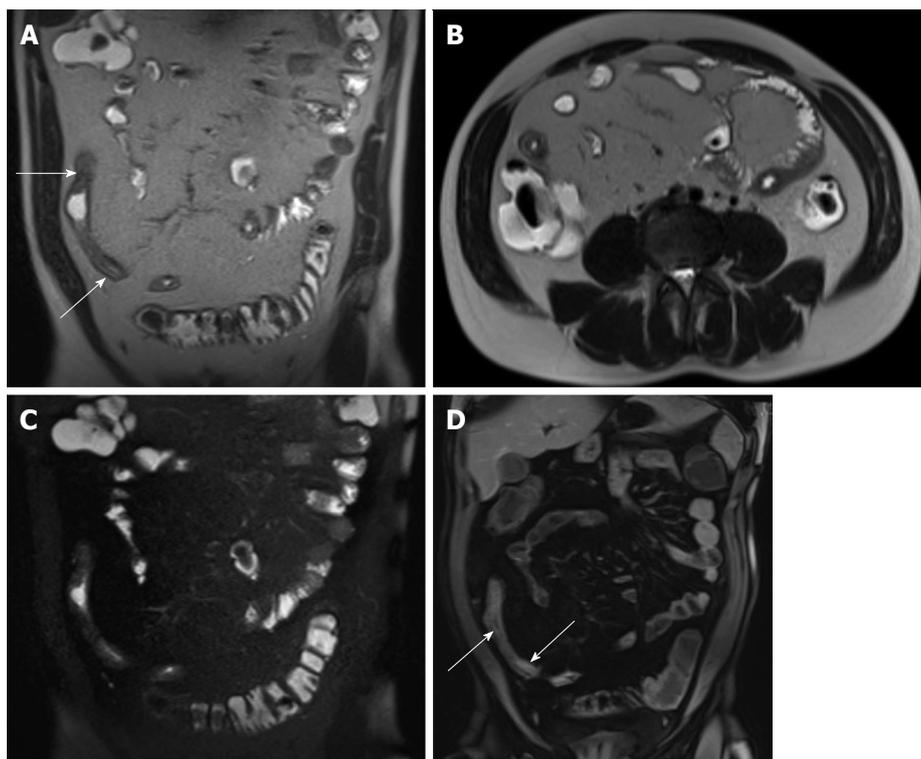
Acute on chronic Crohn's disease. A: Coronal and (B) axial T2-weighted single shot fast spin echo (SSFSE) as well as (C) coronal fat-suppressed T2-weighted SSFSE and (D) coronal fat-suppressed interstitial post-gadolinium 3D-GRE T1-weighted images during the interstitial phase. There is distal small bowel segment which demonstrates diffuse thickening and luminal narrowing (arrows, A), associated with submucosal high signal intensity on T2-weighted images (A and B) and with low-signal intensity on the fat-suppressed T2-weighted images (C), related to submucosal fat deposition, in keeping with chronic Crohn's disease. There is also a superimposed increased mucosal enhancement in affected bowel segments (arrows, D) and comb sign post-gadolinium images (D), reflecting disease activity, in keeping with acute on top of chronic disease. GRE: Gradient recalled echo.
